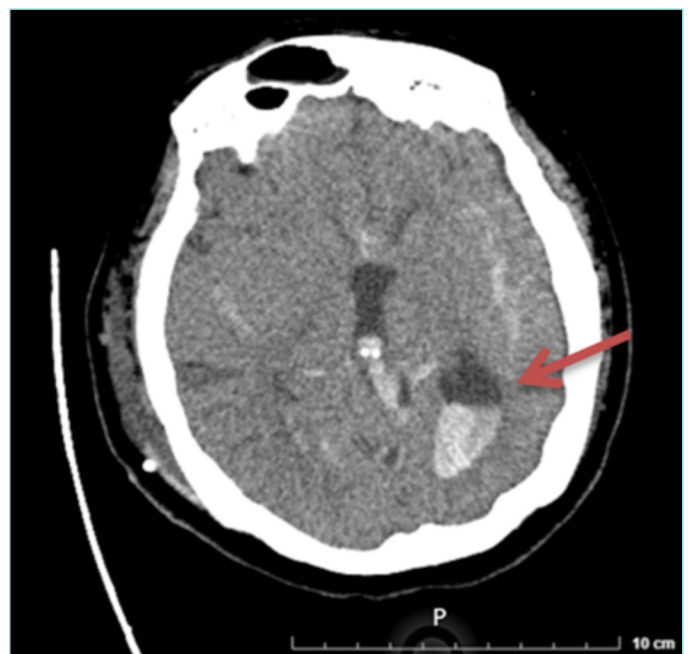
Non-contrast brain computed tomography demonstrates extensive subarachnoid hemorrhage with intraventricular extension (red arrow), ventriculomegaly, and erosion of the left clivus, suggestive of chronic structural changes.
